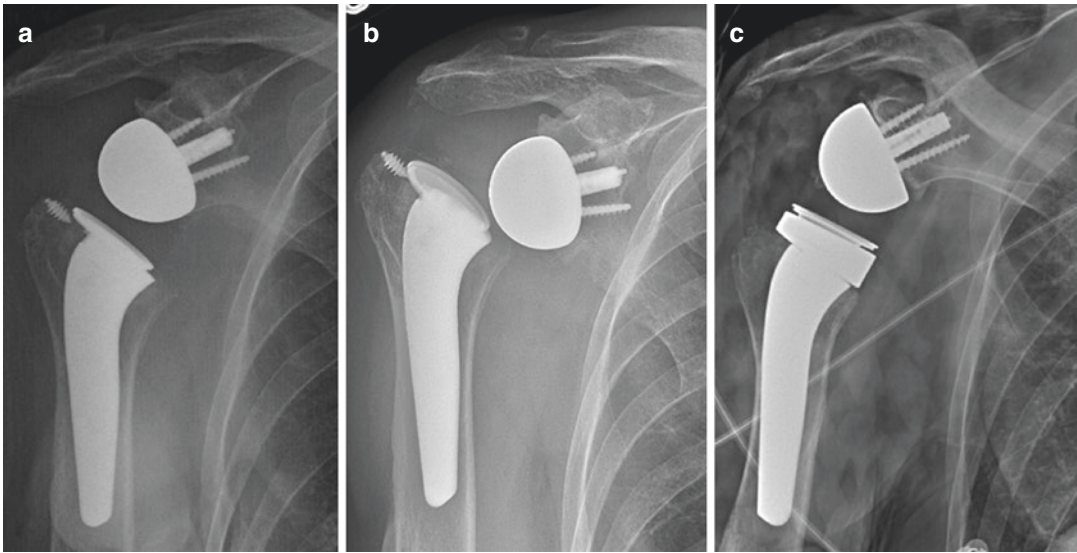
Radiographic evaluation and management of RTSA instability. (a) Immediate postoperative Grashey view of RTSA without evidence of instability. (b) 9 weeks post op Grashey view shows dislocated RTSA prosthesis. (c) Postoperative Grashey view after revision of humeral
